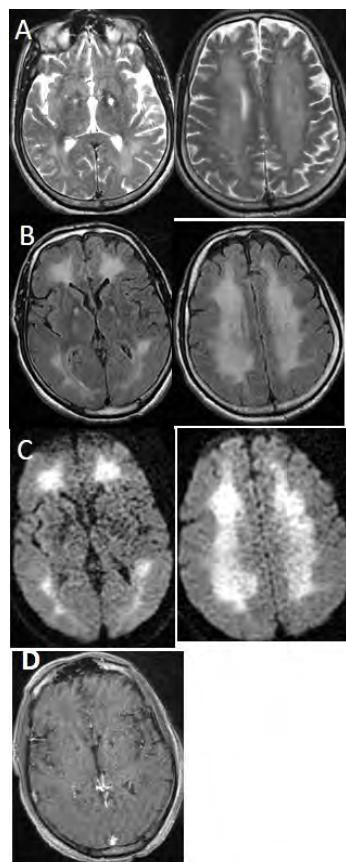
Brain MRI (A) axial T2-weighted, (B) axial fluid attenuation inversion recovery (FLAIR) images, and (C) proton density-weighted show bilateral symmetric extensive hyperintensities in the periventricular white matter, in the posterior limb of the internal capsule, in the centrum semiovale and the globus pallidus. Axial T1-weighted image with contrast (D) shows hypointense bipallidal lesion.
